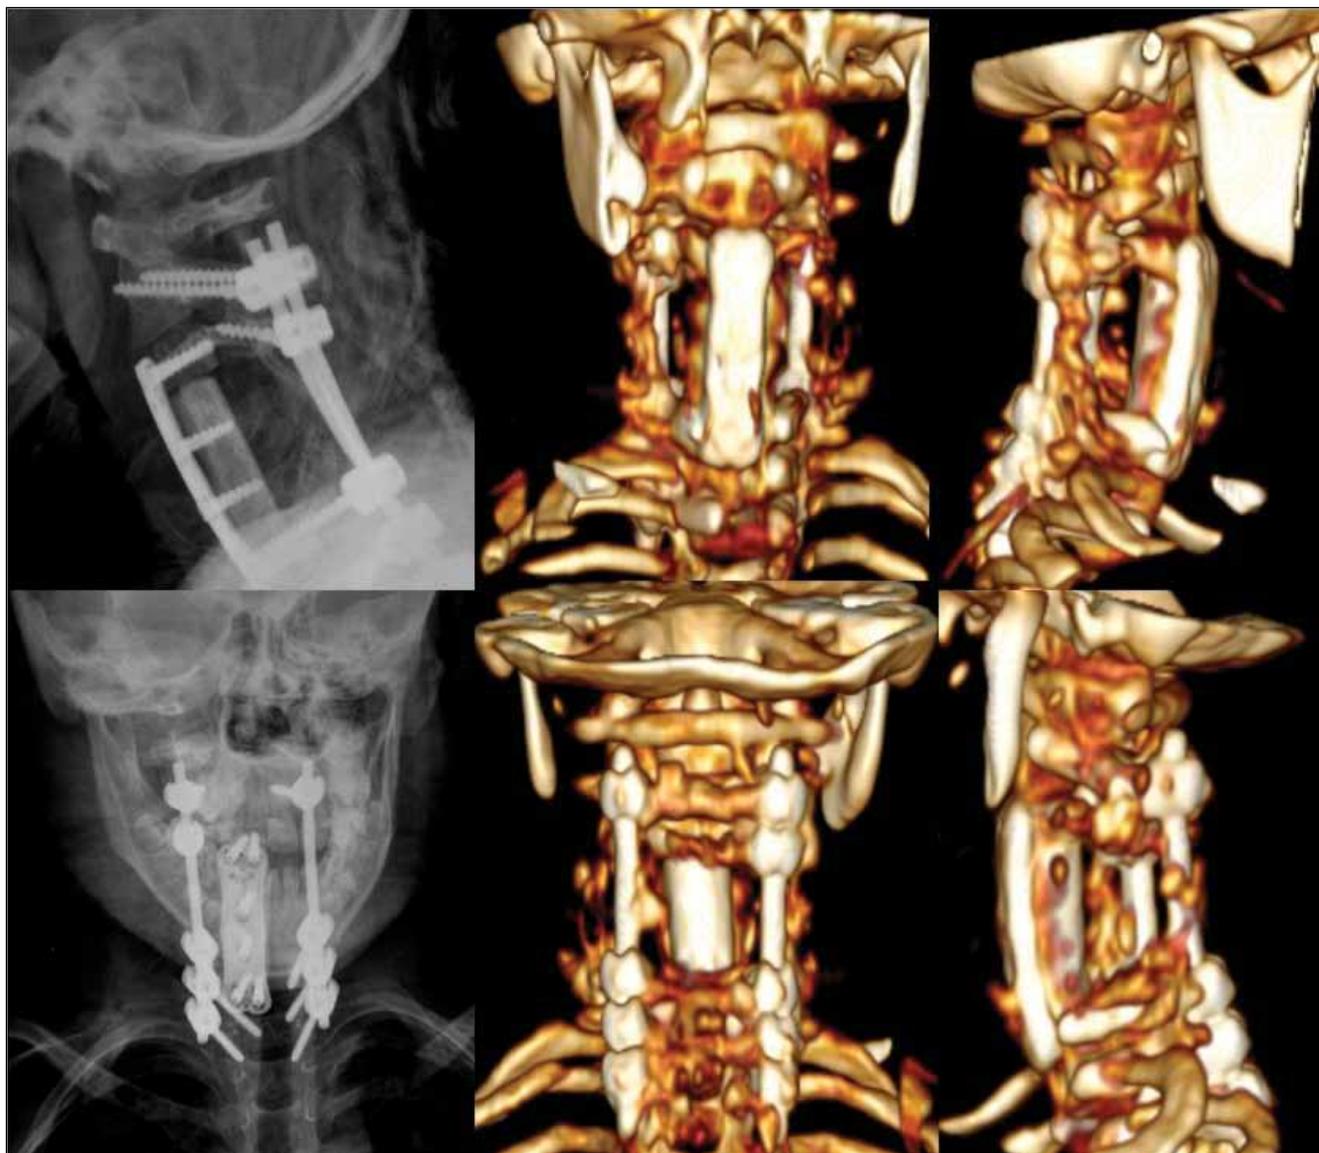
Postoperative direct roentgenograms and 3D reformatted CT images disclosed three level spondylectomy, 360° instrumentation, and correction of the deformity.
